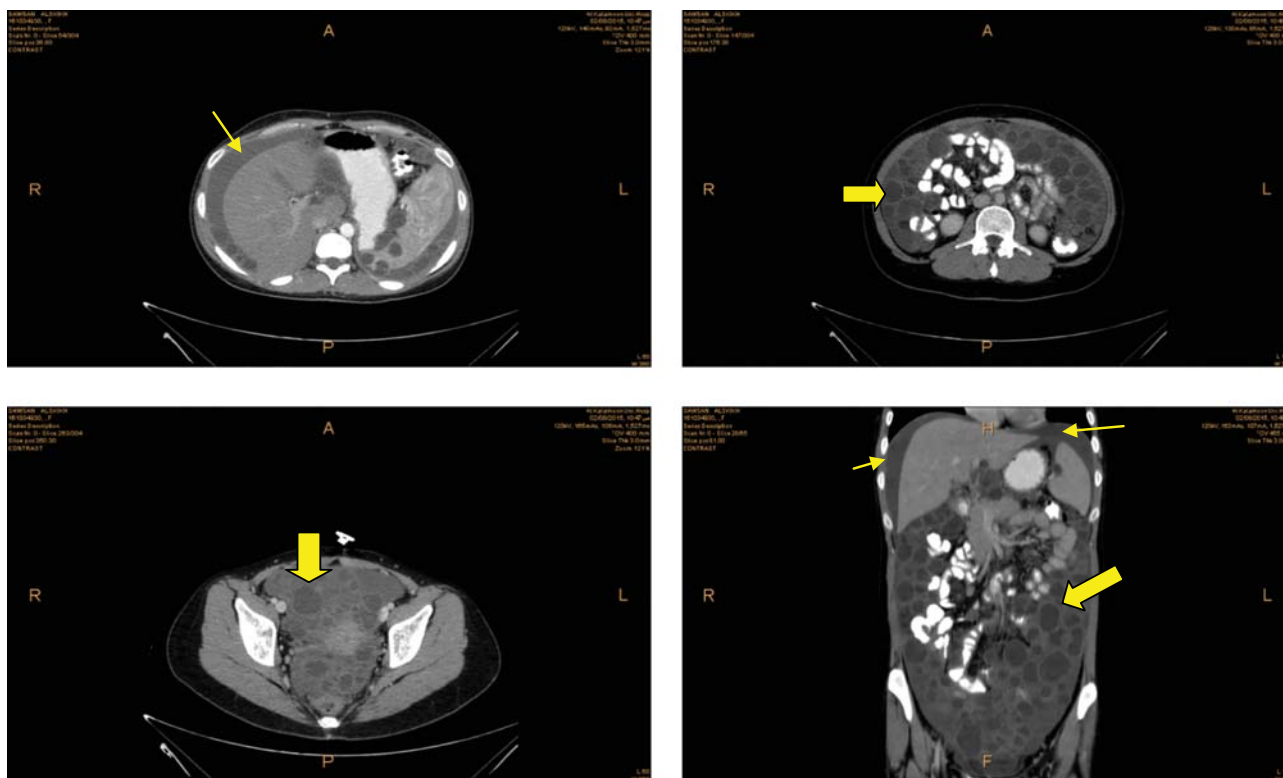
CT scan of the patient before treatment. The imaging shows a huge number of cysts occupying the entire peritoneal cavity with free fluid around the liver and spleen. The narrow arrows indicate free fluid, while the wide arrows indicate abdominal cysts.
